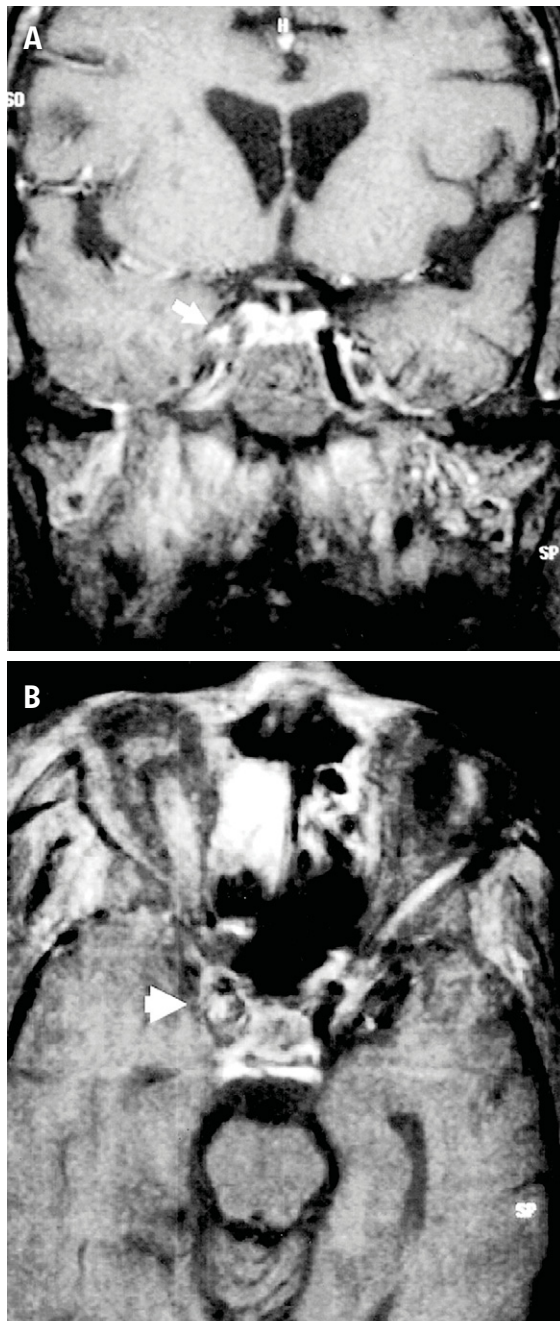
Case 7: (A) coronal T1-weighted magnetic resonance imaging (MRI) (TR/TE: 980/14) with Gd-DTPA contrast enhancement demonstrates diminished caliber and flow-void of the distal portion of the right internal carotid artery at the cavernous sinus segment (arrow). The right cavernous sinus discloses mild enlargement with abnormal enhancement. (B) Axial T1-weighted MRI (TR/TE: 980/14) with Gd-DTPA contrast enhancement shows abnormal signal intensity and enlargement at the right cavernous sinus, diminished caliber and flow-void of the distal portion of the right internal carotid artery at the cavernous sinus segment (arrowhead) and thickening mucosa and fluid collection in the right ethmoid sinus.
